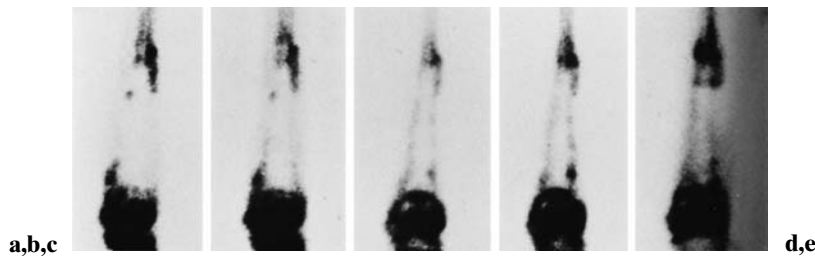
Bone scintigram of the left femur after surgery. a Two months after initial surgery. b Three months after surgery. c Six months after surgery. d One year after surgery. e Two years after surgery. Radioactivity accumulation was observed at the proximal and distal sites of the junction on the initial scan. At 6 months after operation, accumulation was observed surrounding the autoclaved bone. As time passed, accumulation gradually subsided
